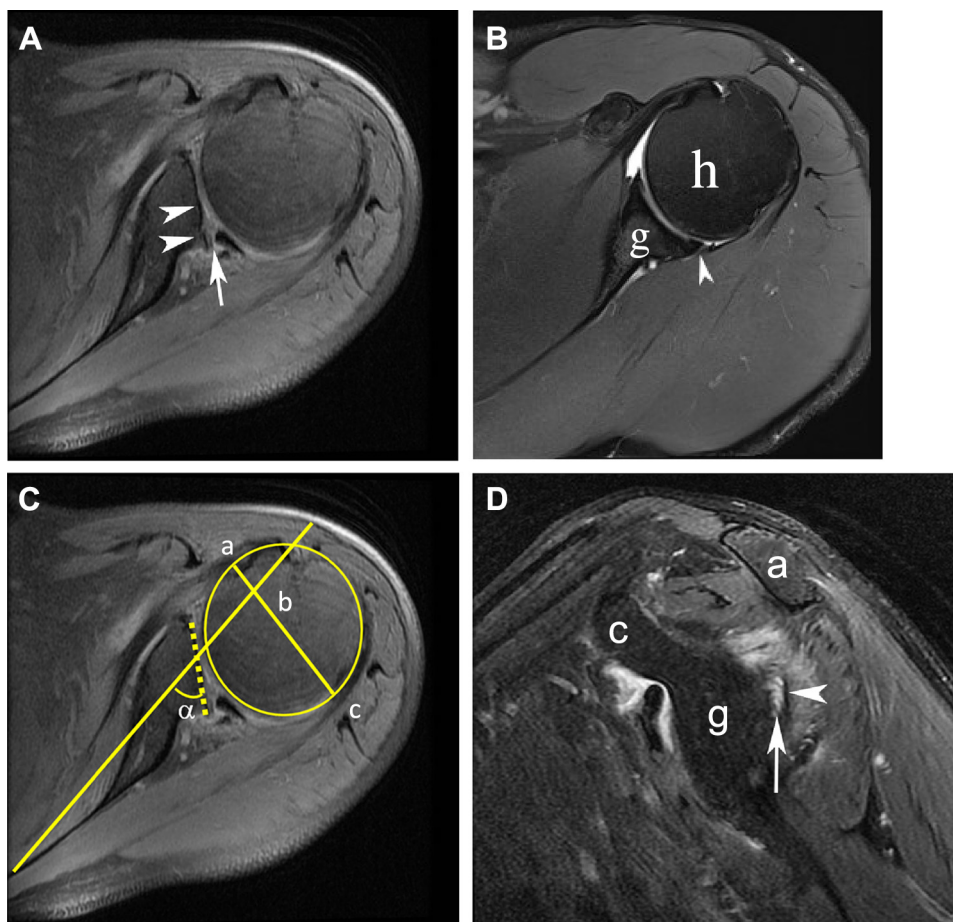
MRI of glenoid hypoplasia in a 43-year-old man. (A) Axial fast spin echo (FSE) proton density (PD) fat-suppressed (FS) image shows hypoplasia of the posterior glenoid (arrowheads), retroversion of the glenohumeral joint, and mild posterior humeral head subluxation. Note the concomitant posterior labral tear, detachment (arrow), and enlargement. (B) Normal shoulder in 40-year-old man. Axial FSE PD fat-suppressed image through the midglenohumeral joint shows the normal glenoid version, posterior labrum (arrowhead), and glenohumeral relationship (g = glenoid, h = humeral head). (C) Retroversion is assessed by obtaining the angle (α) between the glenoid articular surface (dotted line) and a line extending through the long axis of the scapula on axial view. Humeral head subluxation is assessed by calculating $(ab/ac) \times 100\%$. The conventional method of assessing glenoid version on cross-sectional imaging was described by Friedman et al [5]. Glenoid version is the angle between the glenoid line (the axis along the anterior and posterior glenoid rim) and the line perpendicular to the scapular axis (along the root of the scapular spine and center of the glenoid line). (D) Sagittal FSE T2 FS image shows the deficient portion of the posterior glenoid with complex joint fluid (arrow) extending between the glenoid (g) and imaged portion of the posterior labrum (arrowhead). c = coracoid, a = acromion.
